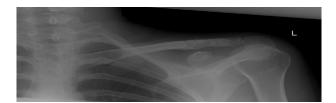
Radiograph after hook plate removal.
